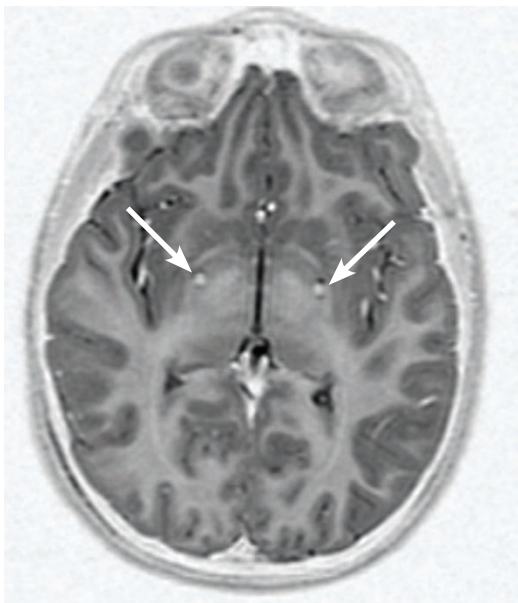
Postoperative axial brain MRI showing bilateral DBS electrode placement (arrows) in the globus pallidus internus of a patient with intractable generalized dystonia.
